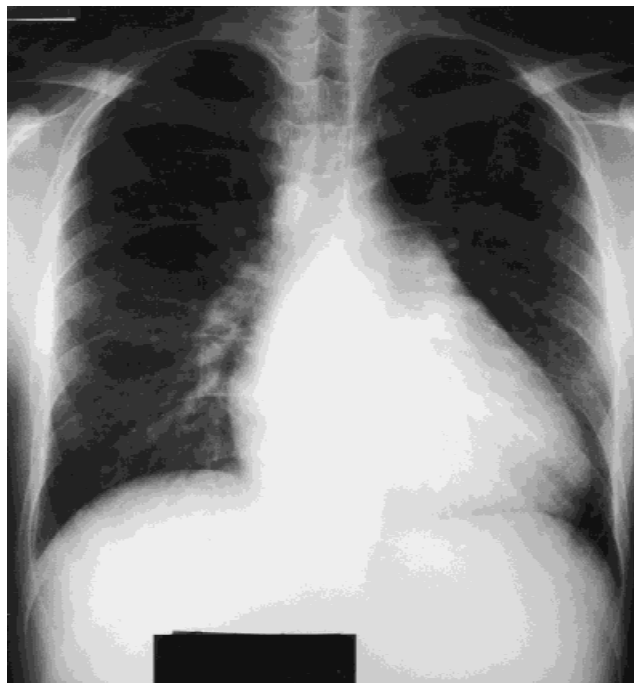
Chest roentgenogram of case 1 on admission.
